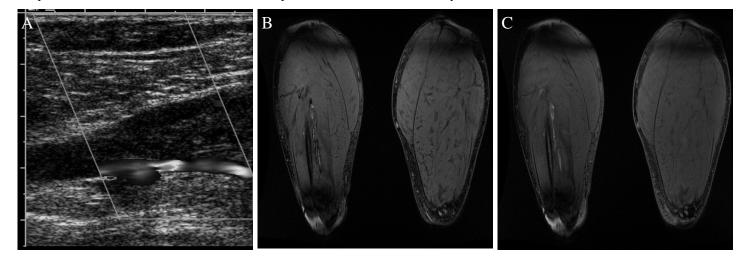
(A) Ultrasound image of the right popliteal vein. (B) MR thrombus image with velocity suppression. (C) MR thrombus image without velocity suppression. Note the improved conspicuity of the DVT in the right peroneal vein in (C) compared to (B). However, the lack of flow suppression suggests that perhaps some of the observed DVT extent in (C) is actually flowing blood.
